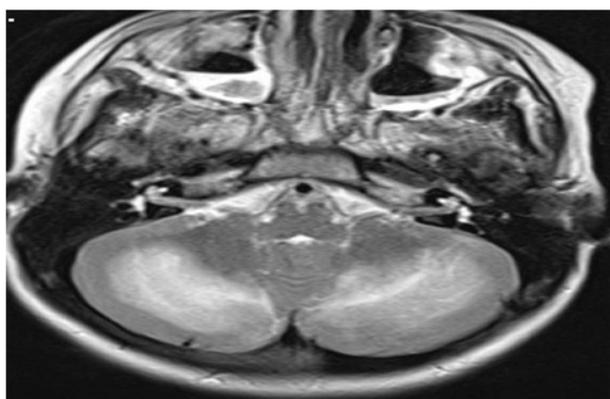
T2 MRI showing bilateral rather symmetrical cerebral and predominantly cerebellar patchy areas of high intensities in T2/FLAIR sequences.
